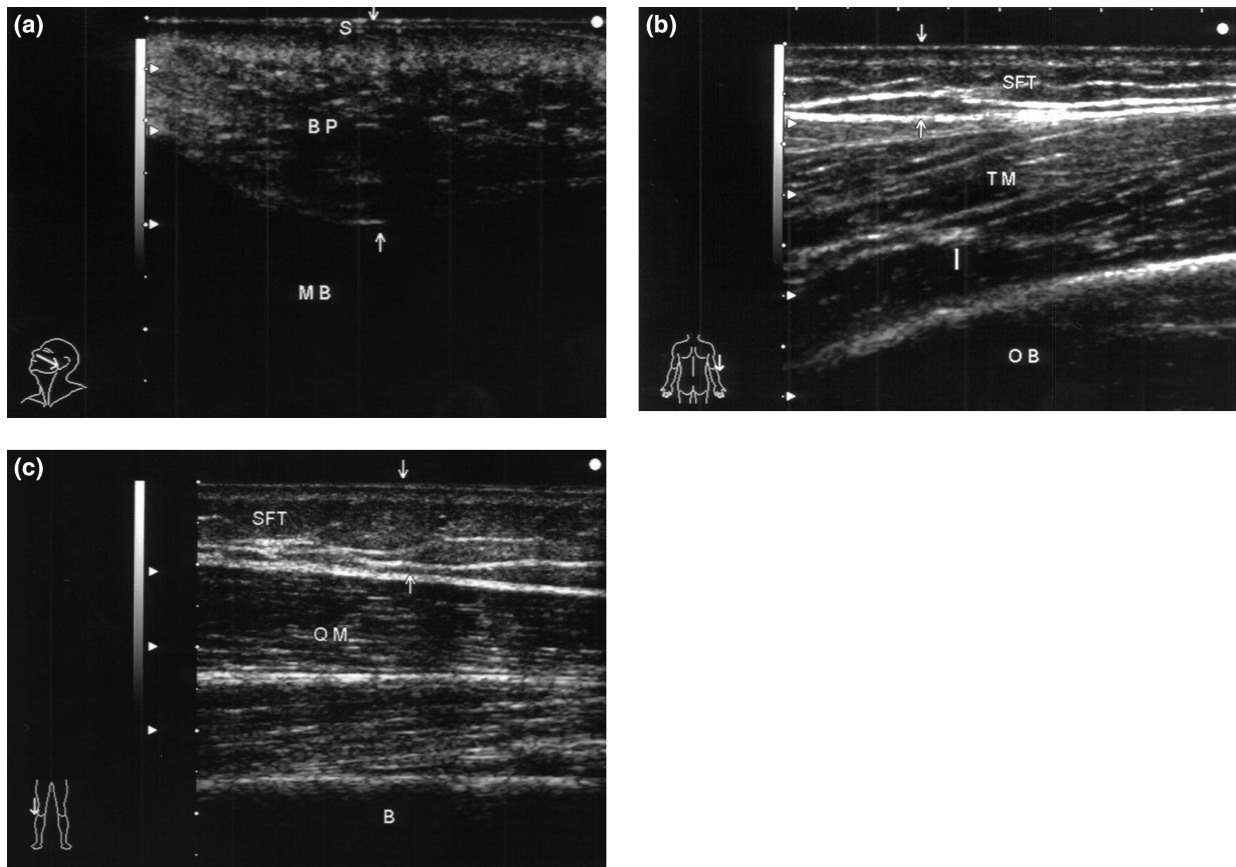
Sonographic “skin reference points” to measuring cutaneous lipoatrophy. US scan with 7.5 to 13 MHz linear transducers is performed without pressing the underlying skin. (A) Facial reference point: SFT is measured with a left nasogenian transversal scan from the malar bone (MB) to the skin (S) on deepest point of Bichat pad (BP). (B) Upper limb reference point: SFT is measured with a long scans 10 cm above the right elbow from superficial wall of triceps muscle (TM) upper omeral bone (OB) to the skin. (C) Lower limb reference point: SFT is measured with long scans 15 cm above the rotula from the superficial wall of quadriceps muscle (QM) upper the femoral bone (B) to the skin.
